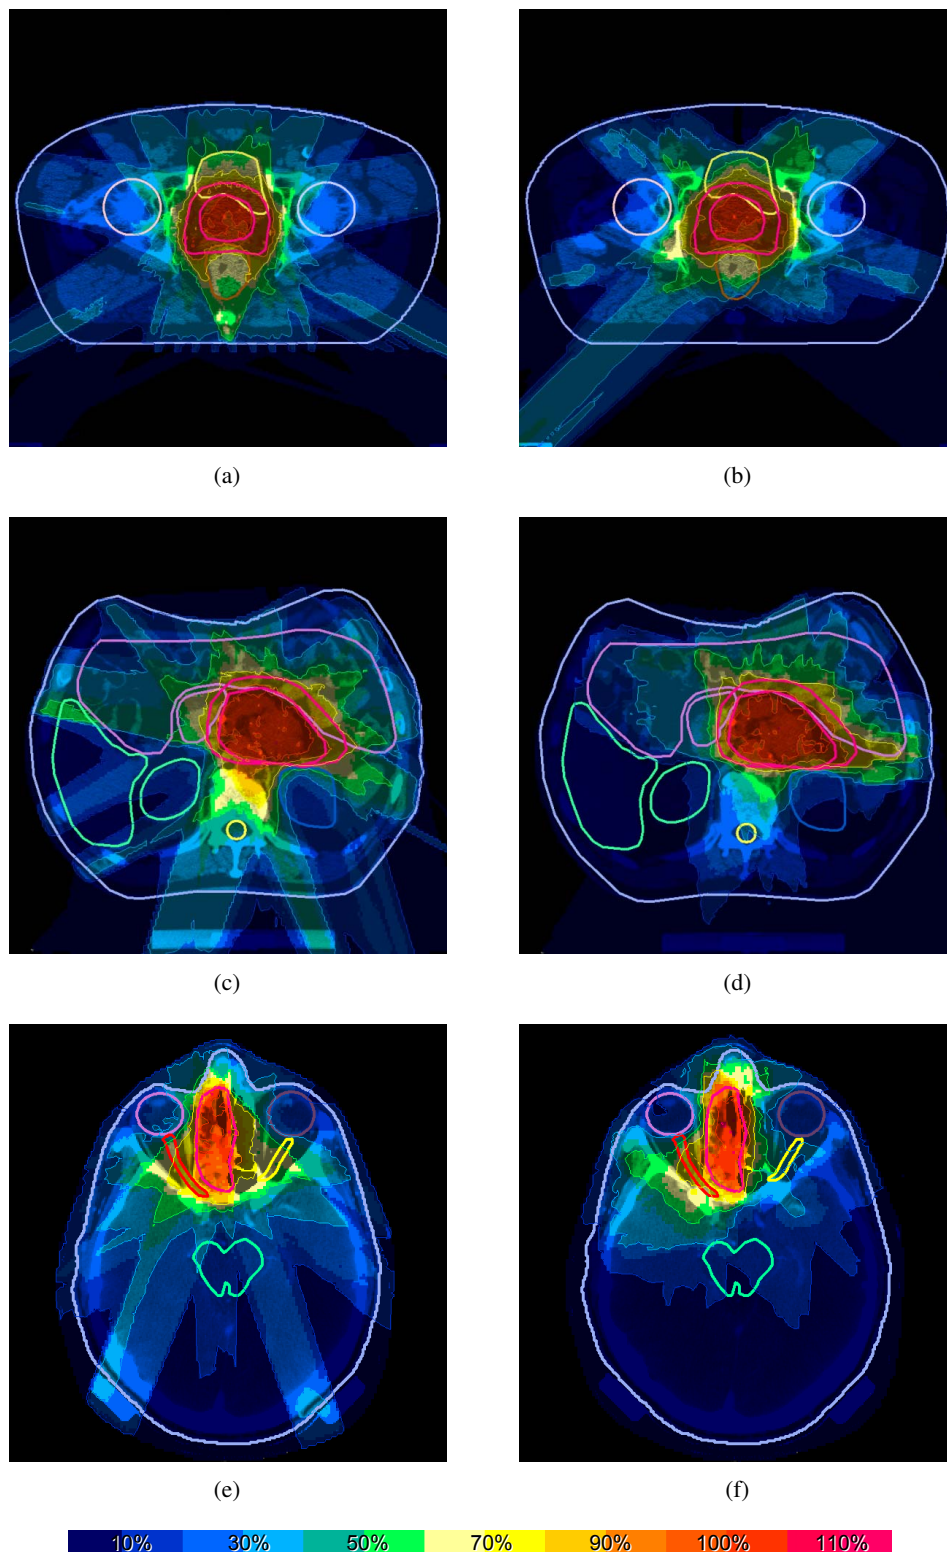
Dose distributions on a selected transversal CT slice for (a) & (b) Prostate lesion II, (c) & (d) abdominal lesion I, and (e) & (f) intracranial lesion II. The dose distributions (a), (c), and (e) are computed with nine equi-spaced coplanar beams, the dose distributions (b), (d), and (f) are computed with nine optimized non-coplanar beams. 100% corresponds to the prescribed target dose.
